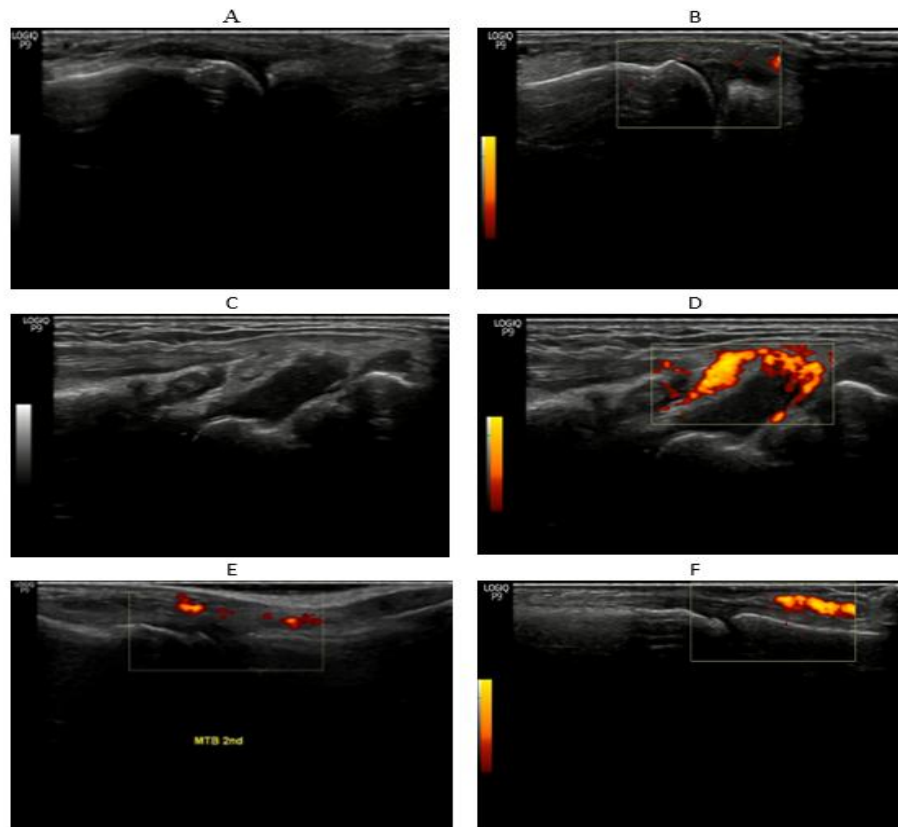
A) Dorsal longitudinal scan showing Tenosynovitis of the 3rd flexor tendon and synovitis of the 3rd MCP joint. (B) Dorsal longitudinal power doppler scan showing Tenosynovitis of the 2nd flexor tendon and synovitis of the 2nd MCP joint. (C) Dorsal longitudinal grey scale ultrasonography of the wrist showing marked joint cavity enlargement due to hypoechoec synovial fluid and hyperechoec synovial proliferation. (D) Power doppler ultrasonography of the wrist showing marked increased vascularity within hypertrophied synovium. (E) Power doppler ultrasonography of the 2nd MTP denoting increased vascularity within the hypertrophied synovium. (F) Power doppler ultrasonography of the 2nd PIP joint denoting increased vascularity within the hypertrophied synovium together with tenosynovitis.
